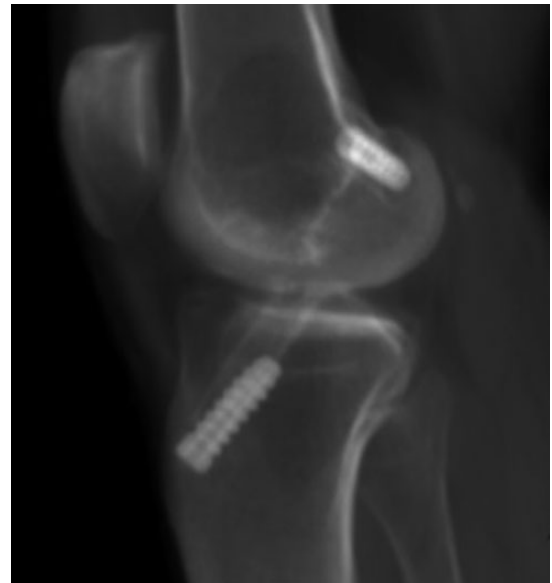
Lateral radiographic knee view showing the anterior cruciate ligament tunnels and the metal screws used for graft fixation. The femoral tunnel was performed close to the anteromedial bundle position.
